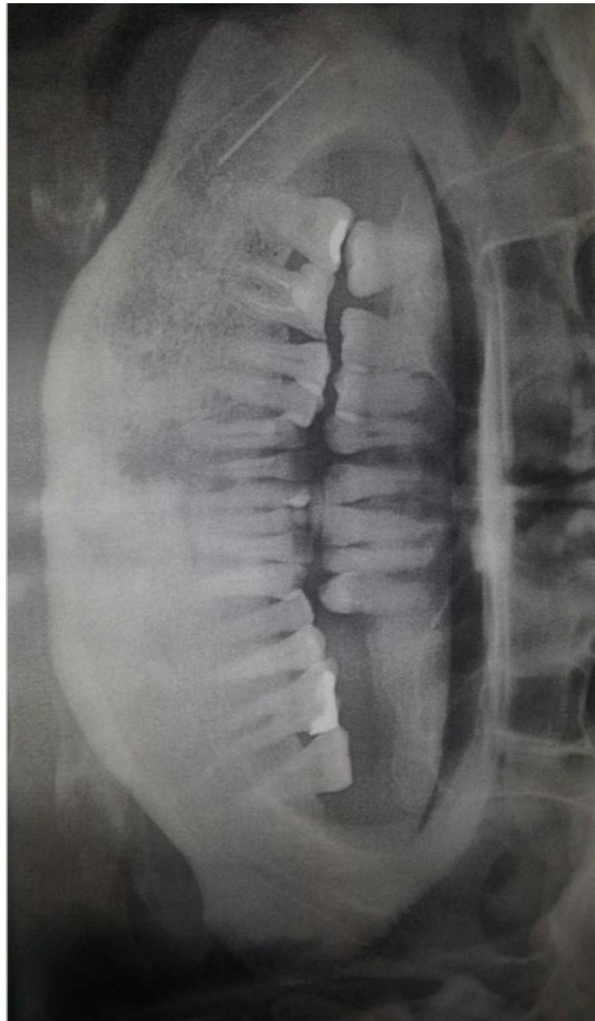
An OrthoPantomogram (OPG) of patient with missing left posterior maxillary teeth and reduced alveolar bone height
